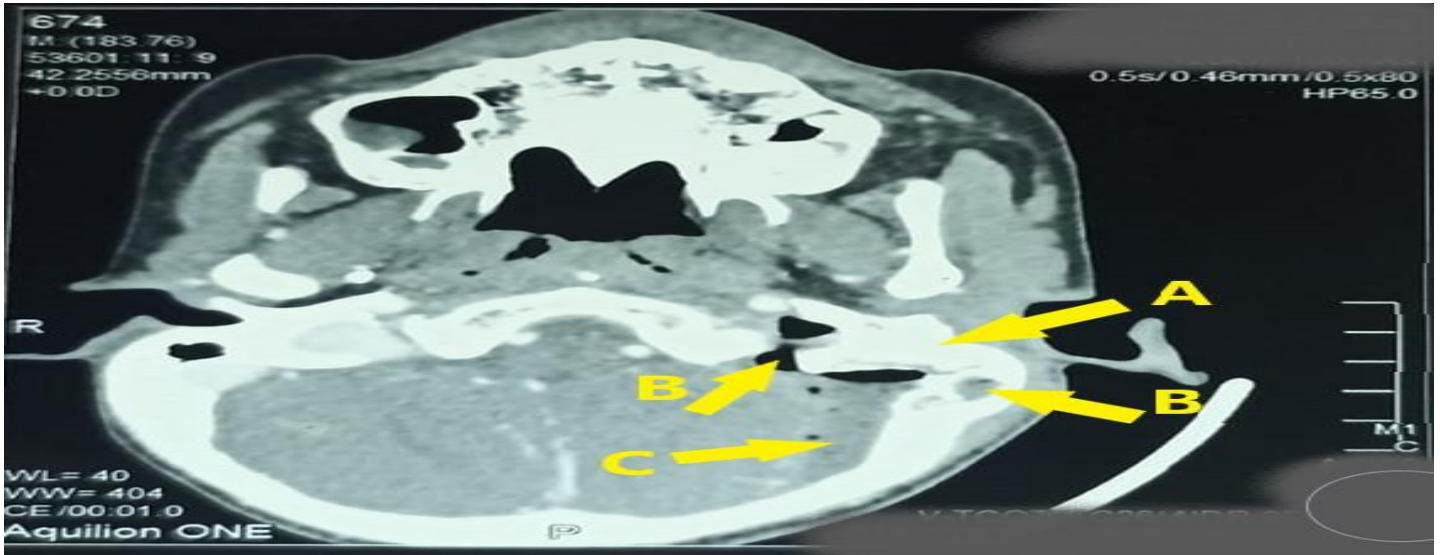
Subdural Abscess: Axial Contrast enhanced CT scan showing increased attenuation of left middle ear and mastoid cavity (A), with large osseous disruption with air trappings along the posterior aspect of mastoid antrum and along the boundary of sigmoid sinus (B) resulting in seepage of exudate in between the meninges, causing a large subdural abscess (C).
